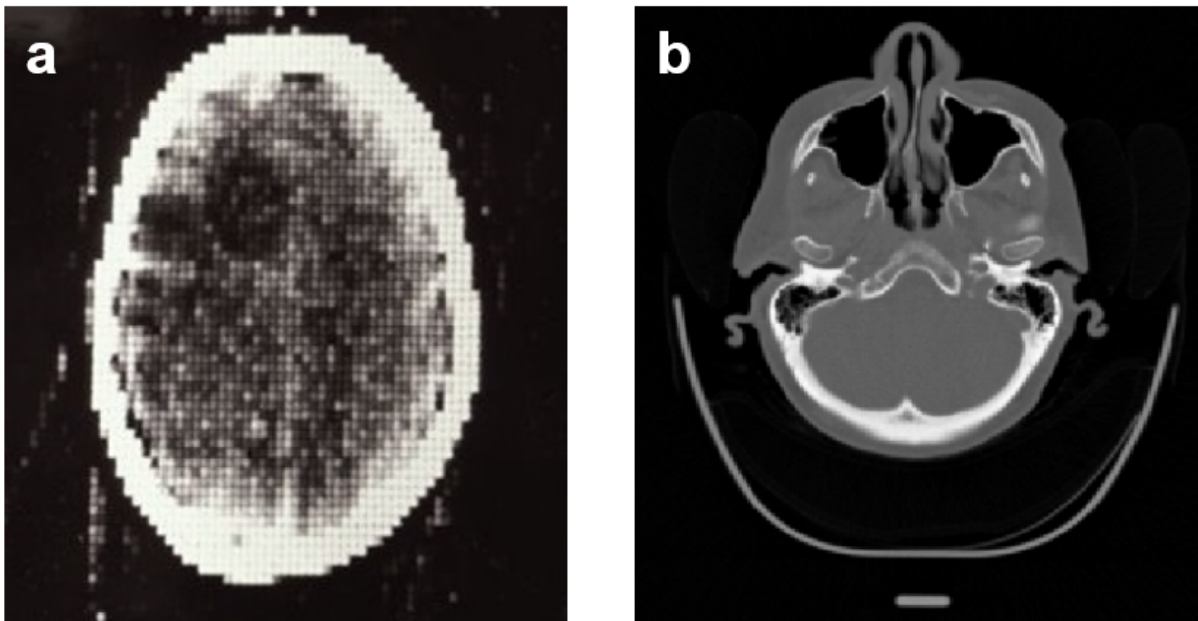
(a) The first clinical CT image which is acquired at Atkinson Morley's Hospital in London (1971) adapted from [87]
